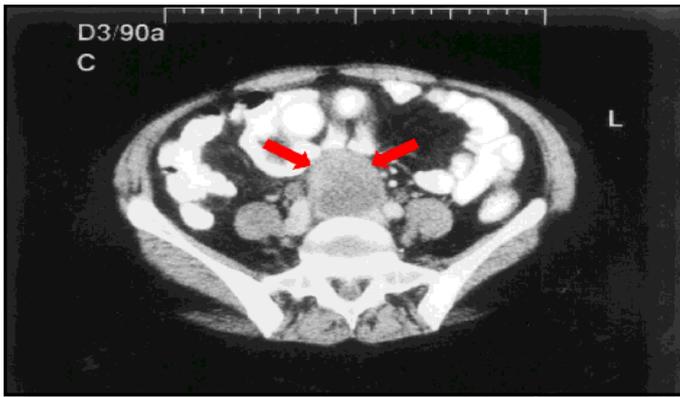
Computed tomography of the abdomen showing an 8 x 7 cm retroperitoneal mass located at the aortic bifurcation.
